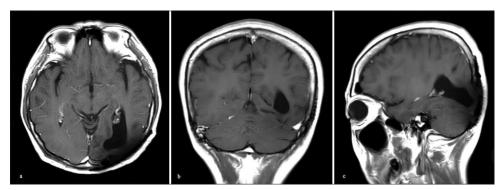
(a-c) Postoperative gadolinium-enhanced head magnetic resonance imaging showed no residual tumor.
